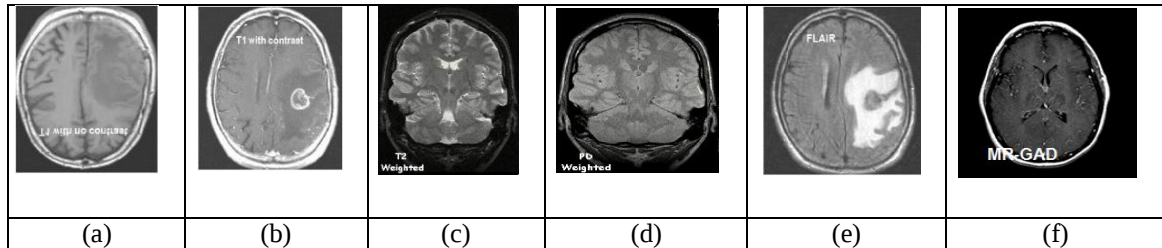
MRI sequences (A) T1W (B) T1C (C) T2W (D) PDW (E) FLAIR and (F) MR-GAD
